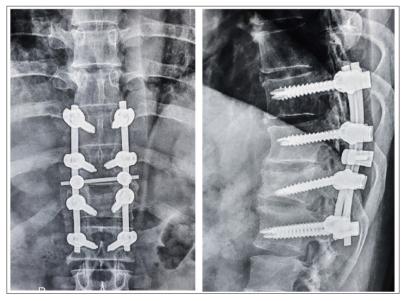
Post operative follow-up X-ray.(Antero-posterior, Lateral view)
